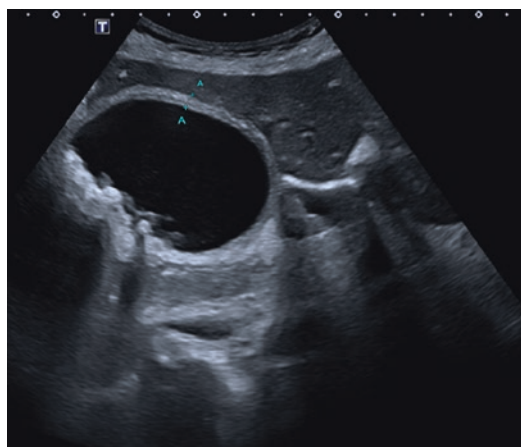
Ultrasound image of acute cholecystitis: characteristic findings are wall thickening with hypoechoic layer, and presence of sludge and gallstones
